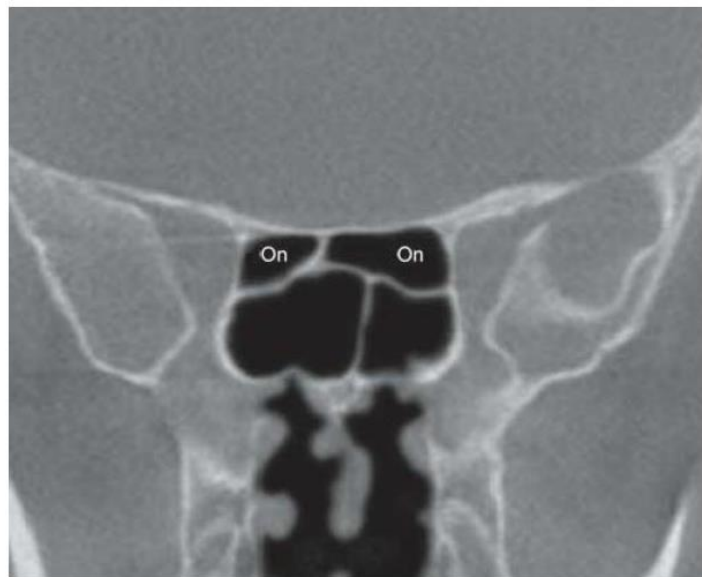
A coronal CT of the sphenoid sinus. Transverse partitions within the sphenoid sinus may indicate the presence of Onodi (sphenothmoid) cells (*asterisk*). These ethmoid cells pneumatize the sphenoid bone lateral to and superior to the sphenoid sinus. They are typically related to the optic nerve and may feature the optic nerve prominently (see Fig. 44.2).
